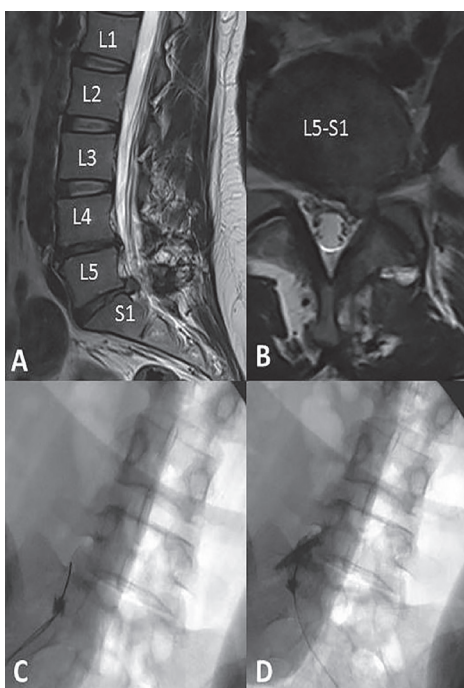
A, B Lumbar Magnetic Resonance Images of L5-S1 left recurrent lumbar disc herniation and C, D Anterior-posterior X-ray graphy images of L5-S1 transforaminal injection
